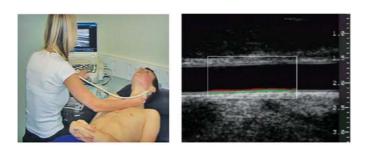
Probe placement for assessment of the carotid artery and example echocardiograph image
